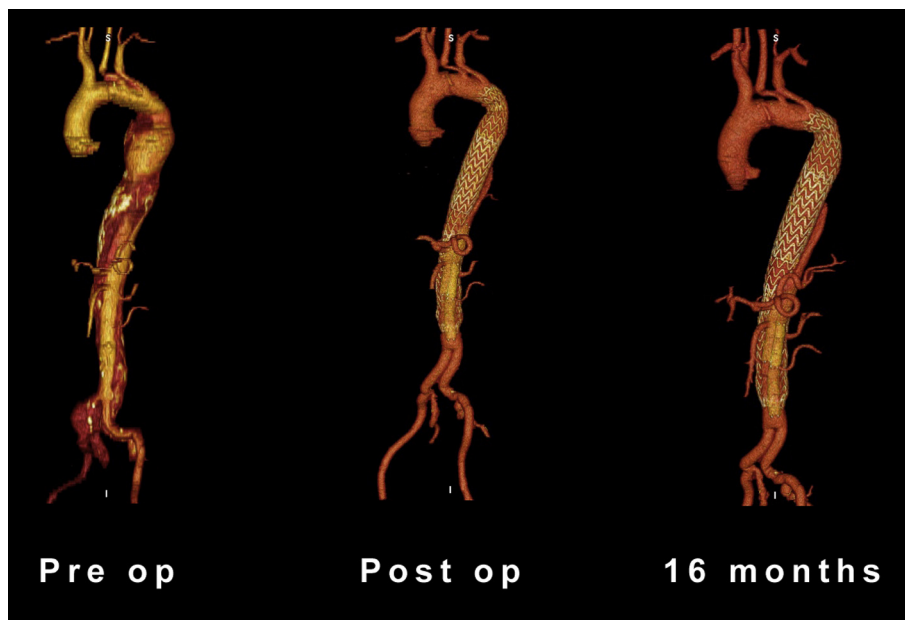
Preoperative, postoperative, and 16-month three-dimensional computed tomography angiography reconstructions. Total coverage of the thoracoabdominal aorta can be appreciated. The celiac trunk and superior mesenteric and left renal arteries are all successfully perfused through true limb salvage using two periscopes.
